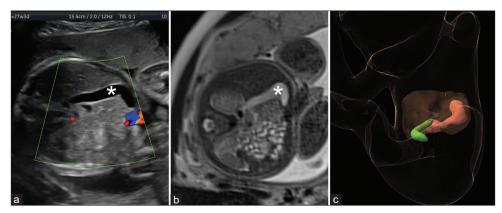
Case 2. (a) Axial view of two-dimensional ultrasound at the 27th gestational week demonstrating the enlarged gallbladder, folded in its distal segment (asterisk). (b) T2-weighted magnetic resonance image (MRI) axial view at the 30th gestational week demonstrating the isointense gallbladder, increased in length, and folding of its fundus (asterisk). (c) Three-dimensional reconstruction from MRI scan data. The elongated gallbladder (green) and its proportion with the liver (brown) and the stomach and duodenum (red)
